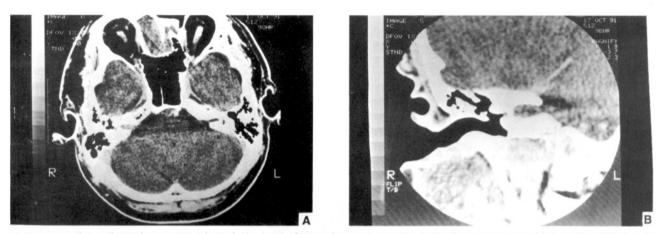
A.B: (Case 2) Axial CT section through the level of IACs shows a contrast-enhanced acoustic tumour filling the right internal auditory canal (A). Magnified standard resolution coronal CT section of the right temporal bone reveals fullness of the intracanalicular space with no significant bony erosion (B).
